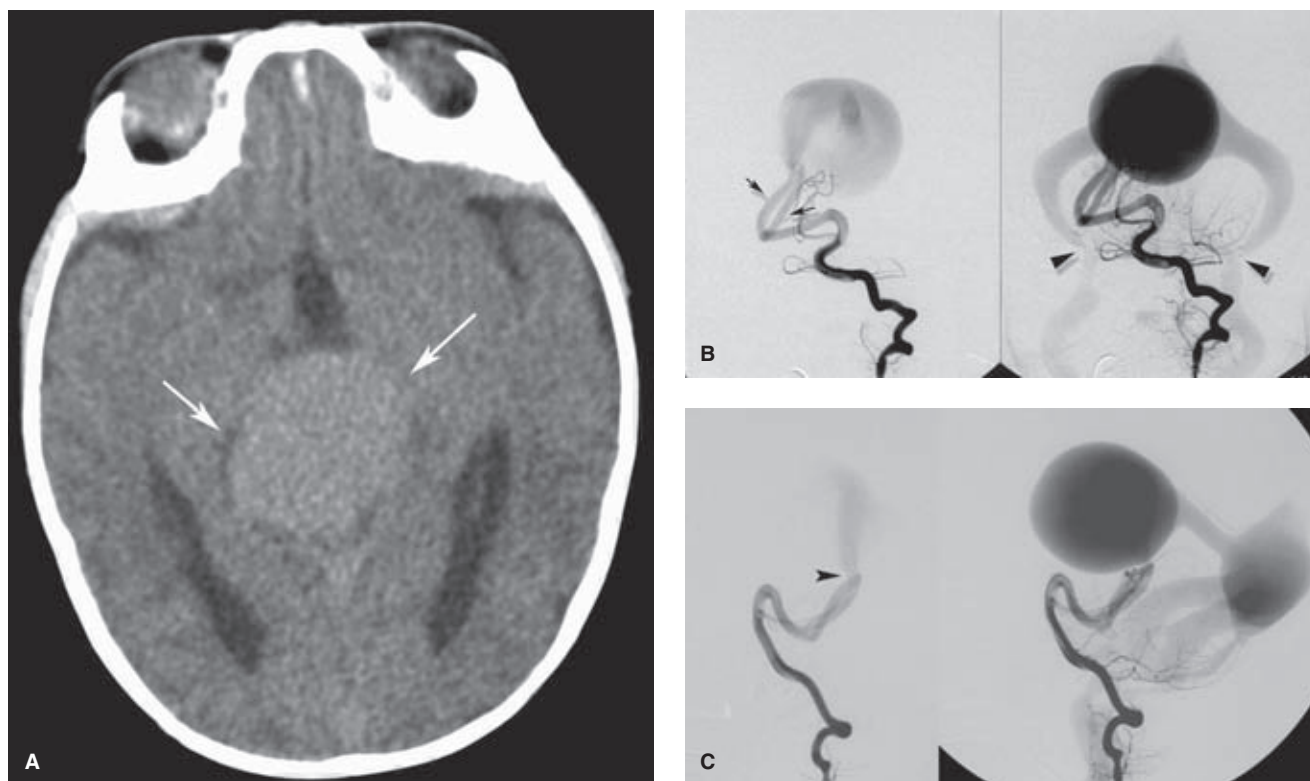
(A–C) Mural-type vein of Galen aneurysm in a 2-month-old child. This vein of Galen aneurysm was detected on a prenatal ultrasound. After birth, the patient had moderate problems with respiratory distress and congestive heart failure that were managed medically with the hopes that treatment could be postponed as long as possible. By 2 months of age, however, there was progressive decline in the capacity of medical measures to control his heart failure, and it was decided to go ahead with endovascular treatment. His pretreatment CT (A) shows mild hydrocephalus with massive distension of the venous sac (*arrows*) of the malformation. Of note particularly is the absence of any signs of irreversible brain damage such as parenchymal calcification or involucional gliosis. The AP views (B) and lateral views (C) of the left vertebral artery injection show that all or most of the flow is via two fistulous choroidal branches on the right side (*arrows*). The force of egress of flow from the arterial to the venous side generates a pronounced jet on the lateral view (*arrowhead*). Relative restriction of size of the straight sinus accounts in part for the marked distension of the “galenic” sac. The jugular confluences of the sigmoid and occipital sinuses demonstrate pronounced restriction of caliber, an observation of debated significance frequently found with this disorder (*arrowheads* in B). This lesion was treated successfully with complete closure of the fistulas using fibered coils. However, 2 years later, the patient returned with a small intraventricular hemorrhage of the III ventricle and was found to have a small degree of recanalization of the lesion requiring further embolization of tiny choroidal feeders. He ultimately needed gamma-knife therapy for unreachable arterial branches, and has since had a normal childhood with no neurologic sequelae.
